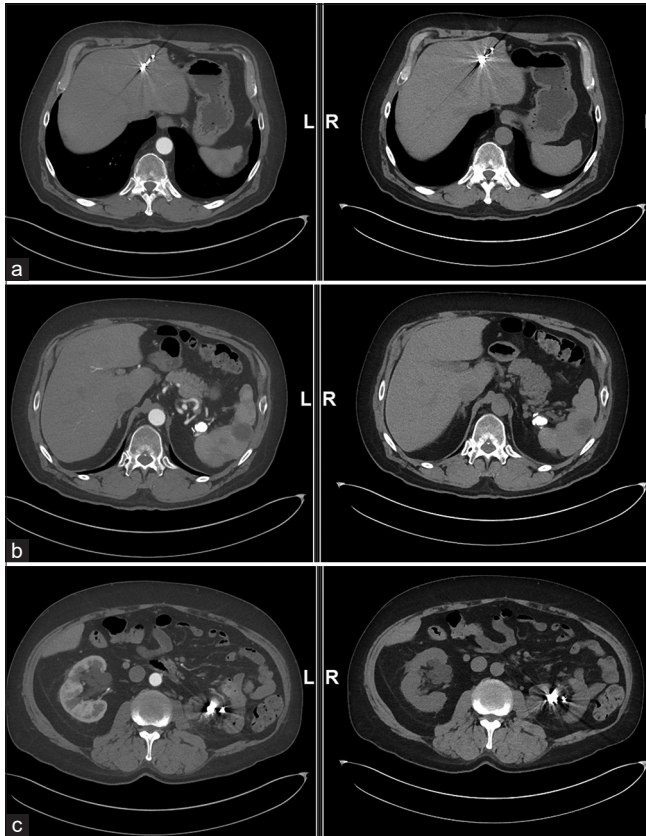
A 52-year-old male with of granulomatosis with history of polyangiitis, left nephrectomy and multiple visceral and brain mycotic pseudoaneurysms status post-endovascular embolization. Follow-up computed tomography (arterial phase on left, delayed phase on the right) 6 months after embolization shows (a) no pseudoaneurysm filling in the left hepatic lobe, (b) splenic artery, or (c) mesentery.
